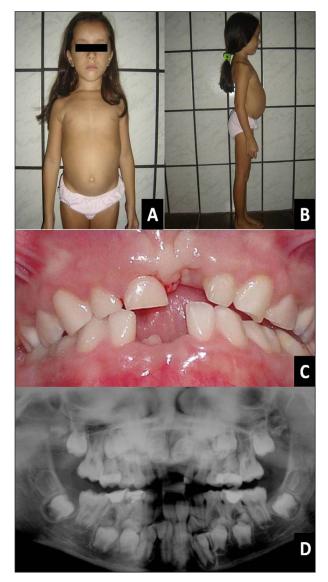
9-year-old female with GHIS with immature development in addition to short stature, large belly (A), and exaggerated lumbar curvature (B). Intraoral photo showing mixed dentition stage (C). Panoramic radiograph showing multiple supernumerary teeth (d).
